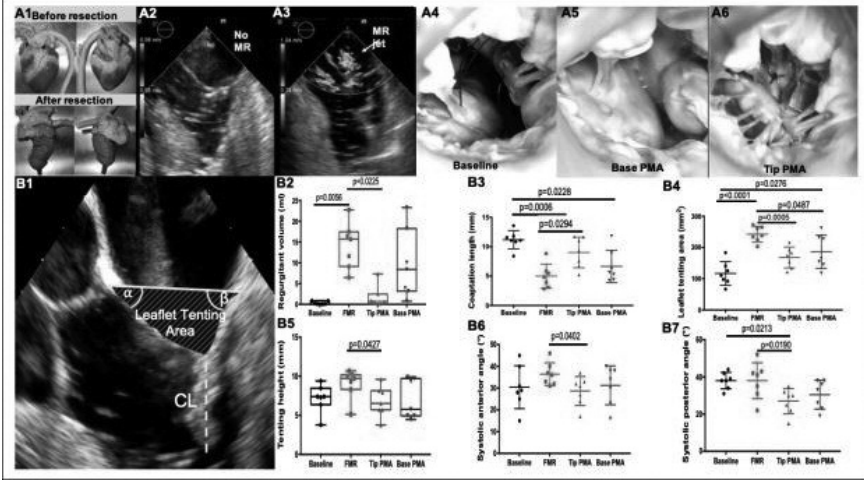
(A1) Representative images of hearts before and after resection; Representative color doppler echocardiography image showing no mitral regurgitation in systole before thinning (A2) and severe mitral regurgitation in systole after thinning (A3); Representative image showing papillary muscles at baseline (A4), papillary muscle approximation (PMA) at bases (A5) and at tips (A6); Mitral valve geometry and function: Representative image showing 2D echocardiography measurements (B1); Regurgitation volume showing regurgitation induced by resection and correction by papillary muscle approximation (B2); Coaptation length (B3) showing reduction by thinning in FMR and improvement by papillary muscle approximation; Leaflet tenting area (B4) and tenting height (B5) showing tethering induced in FMR and relieved by tip papillary muscle approximation; Systolic anterior angle (B6) and systolic posterior angles (B7) showing restoration of leaflet mobility by tip papillary muscle approximation.
